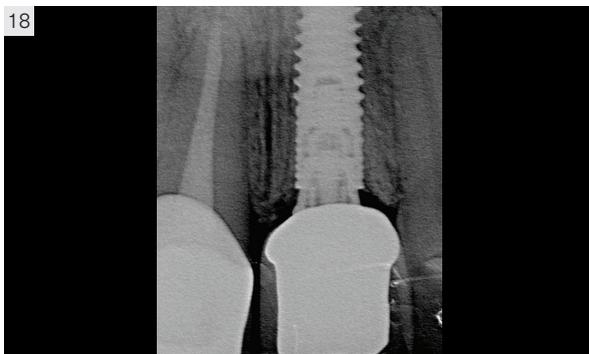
Final clinical and radiographic result. Two zirconia-based ceramic crowns were fabricated for bonding on tooth #11 and for implant #21 to be screwed into the CONNECT abutment. (CDT: Nondas Vlachopoulos)
